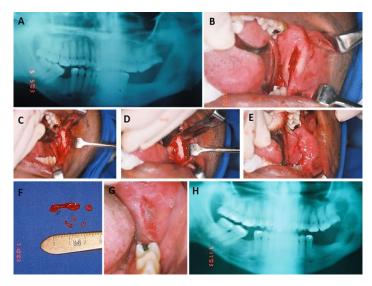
Exposure of the lesion (A); Enucleation of the lesion (B); Application of refrigerant gas, cryotherapy (C); Aspect of the surgical site after cryotherapy (D); Final suture (E), Aspect of the soft tissue of the region within 30 days postoperatively (F); Panoramic radiography of follow-up 2 months postoperatively (G).
